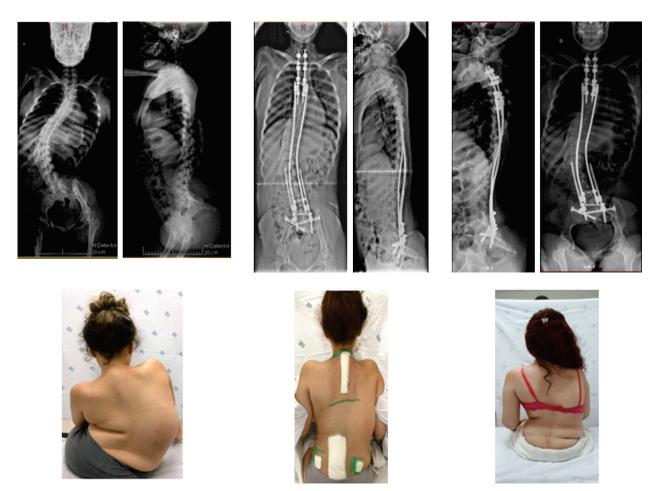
Radiographs and photos of a 15-year-old female patient with progressive spinal amyotrophy. From left to right: preoperative, immediate postoperative, and 1-year follow-up (Source: author's own archive)
